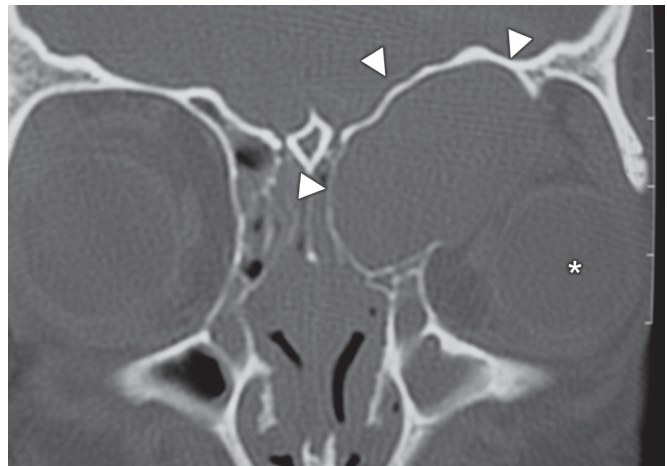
Coronal CT scan demonstrating left frontal sinus mucocoele with expansion into the ethmoid sinuses. Note the bowing of thin bone (arrowheads) and inferolateral displacement of the globe (asterisk).
